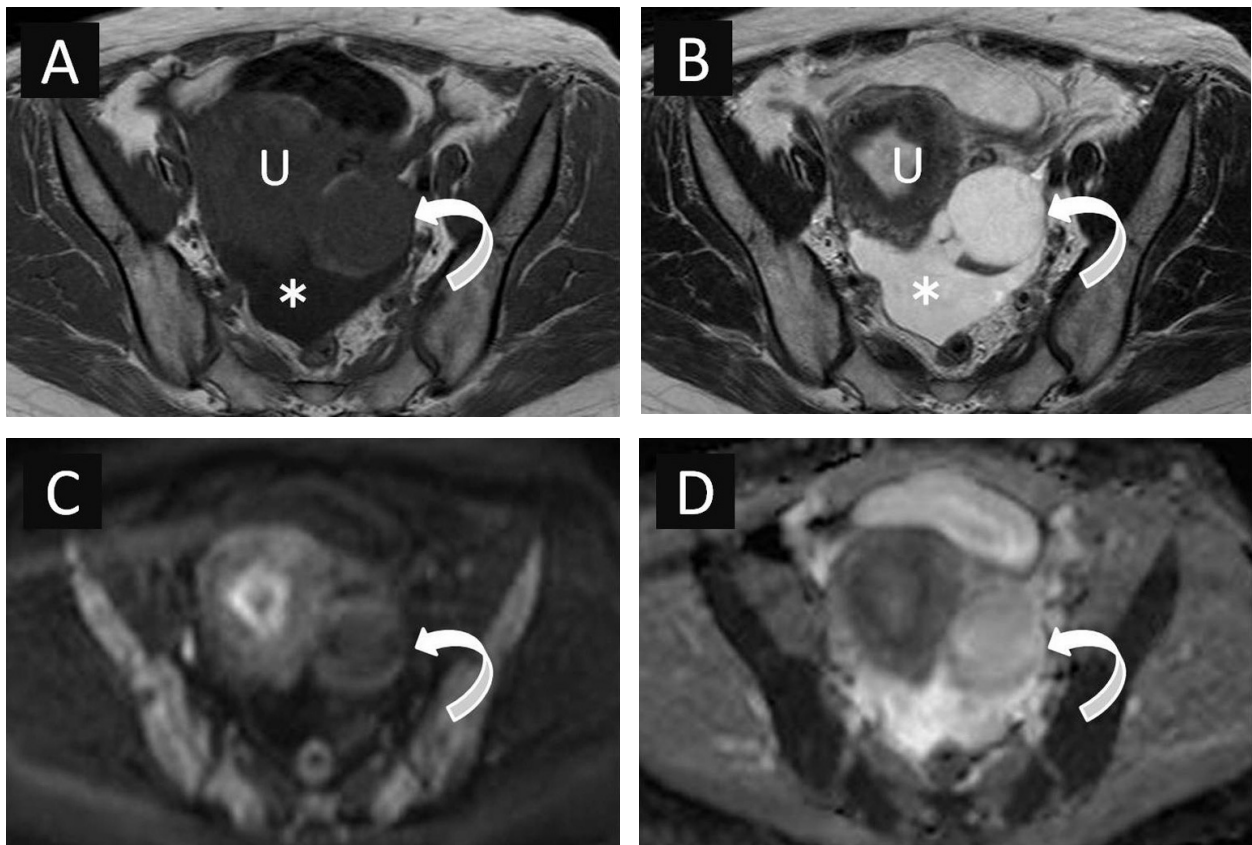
A, On this axial T1-weighted spin-echo MR image at a more caudal level than in Figure 1A, the inferior part of the tumor shows a multicystic appearance (curved white arrow). Note that the signal intensity of each loculus is different, varying from high to low signal intensity. U, uterus; *asterisk*, ascites in the pouch of douglas. B, On this axial T2-weighted fast spin-echo MR image at the same level as in Figure 2A, the inferior part of the tumor shows a multicystic appearance (curved white arrow). Note that the signal intensity of each loculus is different, varying from high to low signal intensity. U, uterus; *asterisk*, ascites in the pouch of douglas. C, On this axial diffusion-weighted MR image ($b=1000 \text{ second}/\text{mm}^2$) at the same level as in Figures 2A and 2B, each loculus shows varied signal intensity (curved white arrow). D, The corresponding apparent diffusion coefficient (ADC) map image at the same level as in Figure 2C. On this axial ADC map image, the loculi show various signal intensity (curved white arrow). The calculated ADC values of each loculus are different from each other, ranging from $1.65 \times 10^{-3} \text{ mm}^2/\text{s}$ to $2.66 \times 10^{-3} \text{ mm}^2/\text{s}$.
